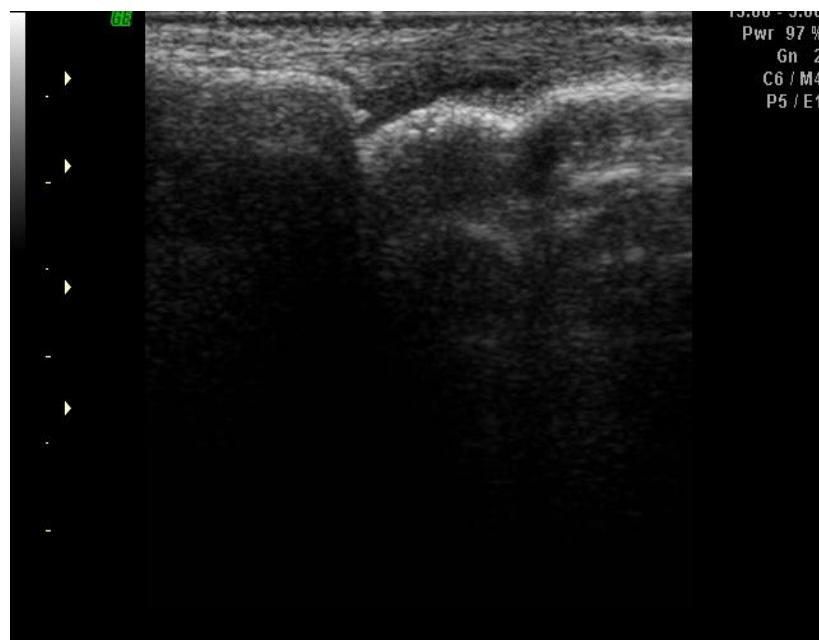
Musculoskeletal ultrasound; joint effusion is highlighted, without Doppler signal.
